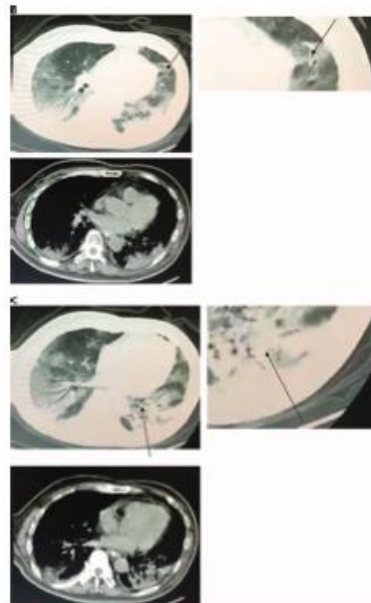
Computed tomographic images obtained from the patient 3 weeks after initial clinical manifestations of COVID-19 and 2 weeks before transthoracic biopsy, demonstrating ground glass-like opacifications.
